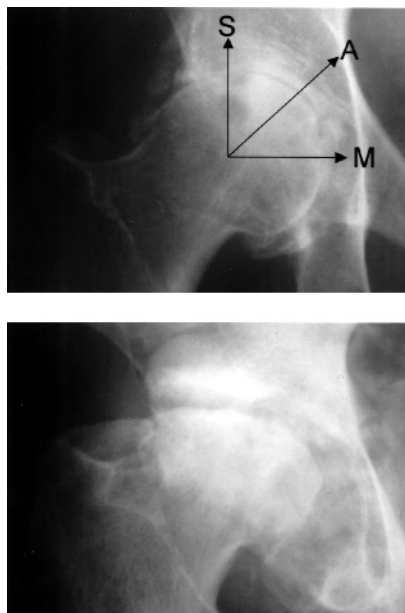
Patterns of hip OA. The top radiograph shows the 3 main patterns of femoral head migration. S: superior, A: axial, M: medial (see text). The lower radiograph shows the "atrophic" pattern of hip OA (marked bone attrition, paucity of osteophytes). OR: odds ratio, THA: total hip arthroplasty. Adapted from Lanyon, *et al.* Ann Rheum Dis 2004;63:259-63<sup>16</sup>.
